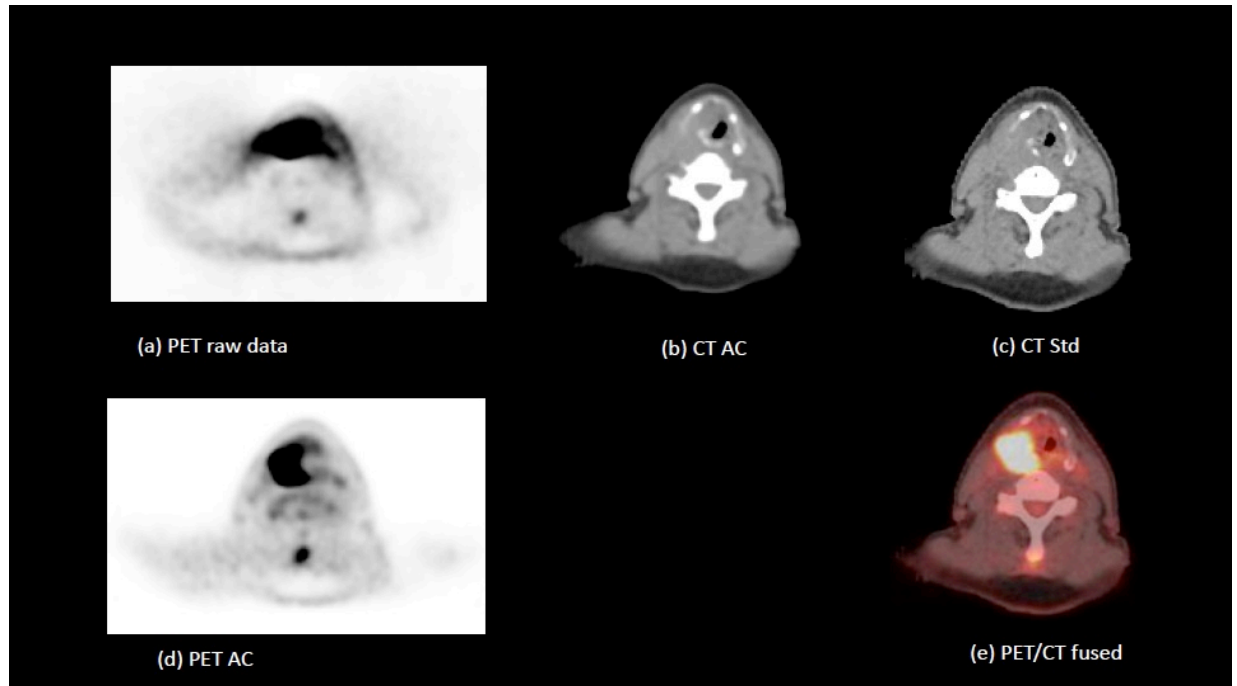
Example of PET/CT acquisition-reconstruction-fusion for a patient with cancer of right pyriform fossa. PET raw data (a) is corrected by the CT Attenuation Correction (b). Attenuated Corrected PET (d) is fused with the Standard CT (c) giving PET/CT fusion (e). Usually CT Std is acquired without contrast. A contrast enhanced CT Std can be used for better anatomical details.
